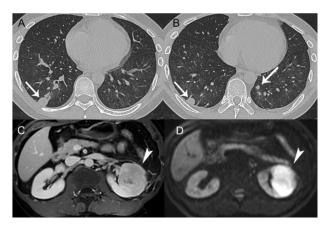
A 32-year-old man presented with a 1-month history of recurrent fever, cough and left lumbago. He also complained of hearing impairment, asthenia, anorexia and arthralgia. The patient was a smoker with a fifteen-year history of smoking about 10 cigarettes a day. Routine laboratory studies were unremarkable, with normal renal function and urinalysis. Clinical symptoms persisted during antibiotic therapy. The enhanced thoracic CT revealed bilateral pulmonary multiple solid nodules without calcification or cavitation (A, B: arrow); and the abdominal MRI exhibited an irregular mass measuring 53x48 mm at the enlarged left kidney. The lesion showed mild to moderate enhancement on postcontrast T1-weighted image and hyperintense signal on diffusion weighted image (C, D: arrowhead). Primary renal carcinoma with pulmonary metastasis was suspected.
